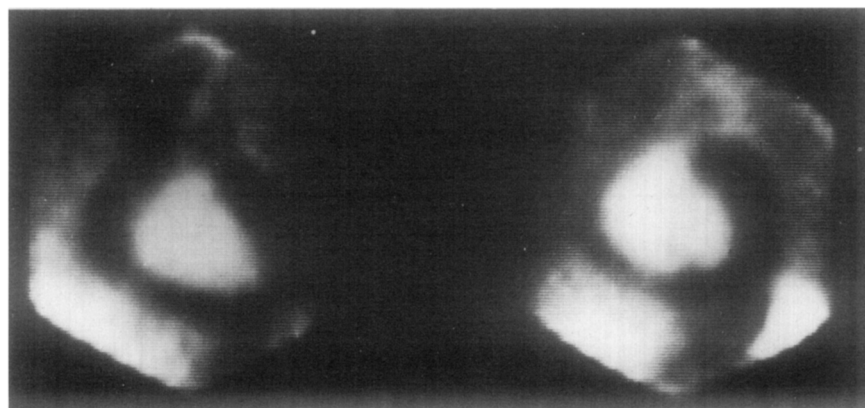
Extension of pericardial effusion (*PE*) behind the left atrium (*LA*) is demonstrated by two-dimensional echocardiography. *LV* = left ventricle; *LAPW* = left atrial posterior wall; *LVPW* = left ventricular posterior wall.
